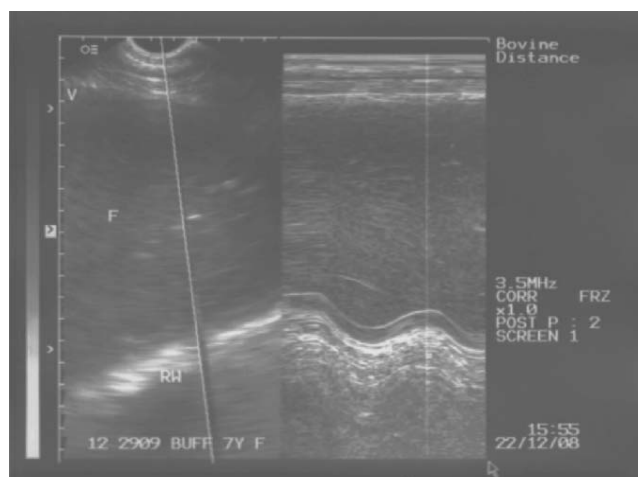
Ultrasonogram in B+M mode showing displacement of reticular wall with peritoneal effusion
